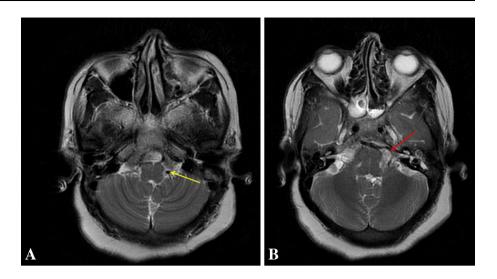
Axial magnetic resonance image (3D FIESTA sequence) showing the left vertebral artery (*red arrow*) taking a tortuous course and impinging on the deep cerebellopontine angle in the area of root exit zone of the left facial nerve (*yellow arrow*)
